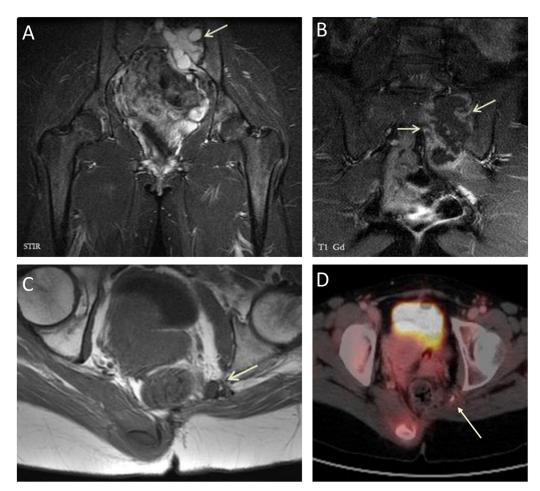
A. 30 years old female with pain in the left hip. STIR (A) MR images show an expansive lesion in the left sacrum with high signal with chondroid appearance (arrow) and poor peripheral enhancement on FS T1WI (arrows in B). The surgically removed piece confirmed a grade 2 chondrosarcoma. Two years after the surgery a recurrent lesion appeared in the remaining sacrum on T1WI (arrow in C) with high uptake on PET-CT (arrow in D). (Color version of figure is available online.)
